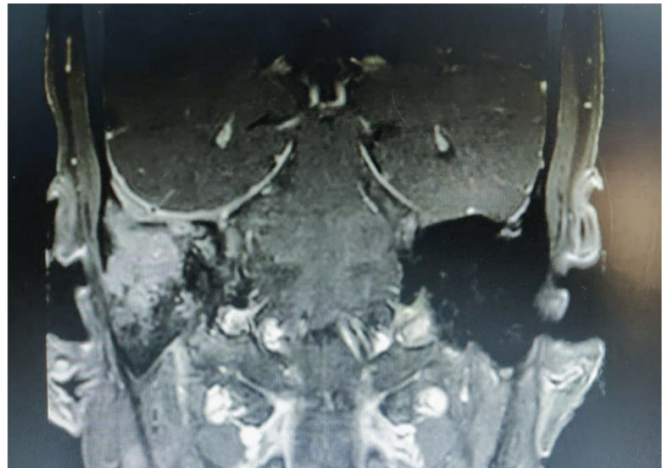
cT1W MRI - Heterogeneous enhancement of right middle ear soft tissue with enhancement of overlying dura
